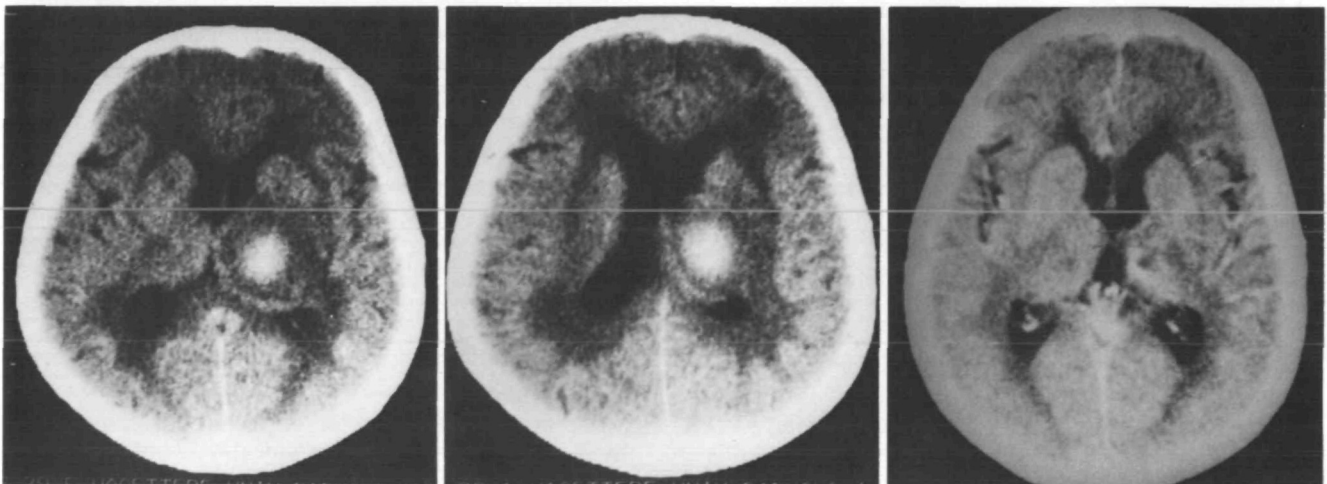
Case 1. Left and Middle: Contiguous computed tomographic (CT) sections of patient with right thalamic hematoma. Beside hemorrhage, note marked degree of diffuse periventricular lucencies (leukoaraiosis) Right: One year after initial event, CT shows cystic area in same location that resembles lacune.
